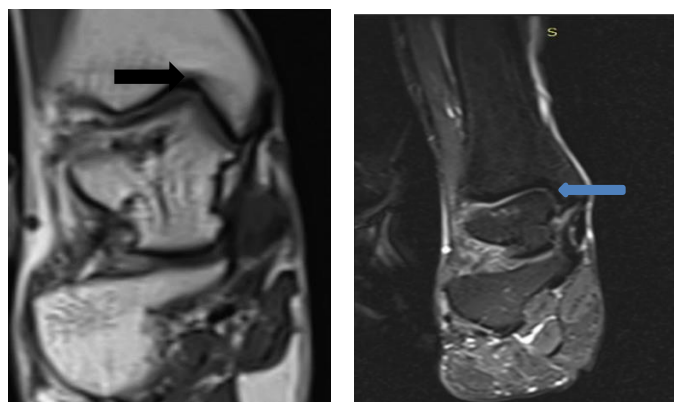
A: Coronal T1 weighted MRI
